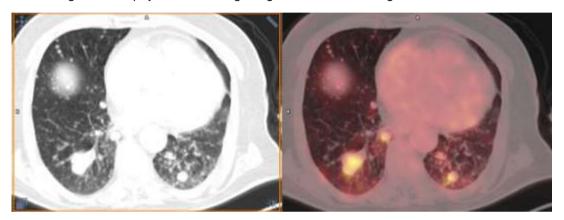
Transaxial CT (a) and fusion image (b) on PET/CT scan showed multiple lung metastases in a 64-year-old male patient diagnosed with a rectal cancer
